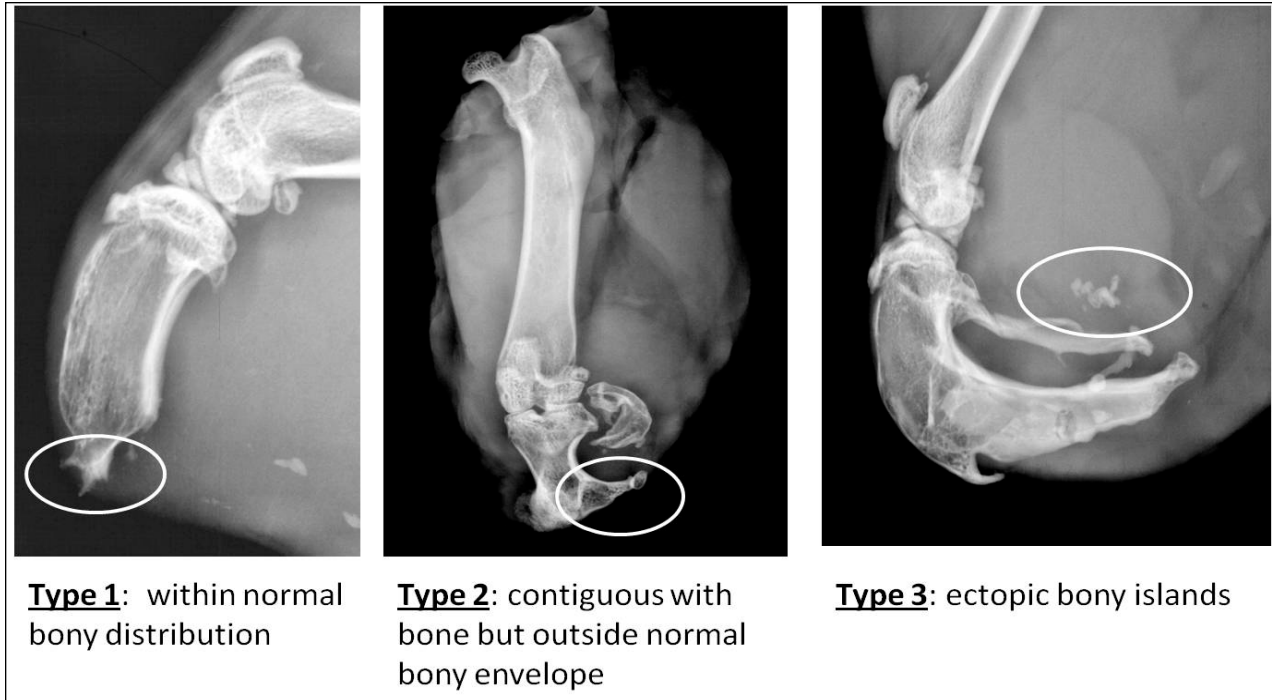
Radiographic key used for grading HO type.
